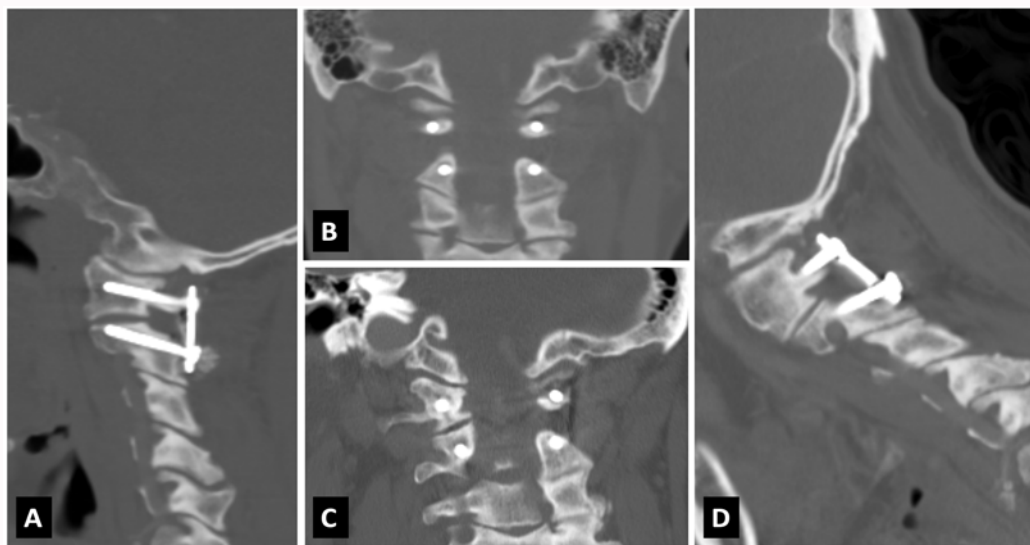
Cervical spine CT in bone window. Sagittal and coronal view of immediately postoperative image (A, B) showed appropriate instrumentation. Comparing with the image one year after operation (C, D), which revealed left C1 posterior arch breach at superior wall with screw exposure and dynamic VA compromise.
